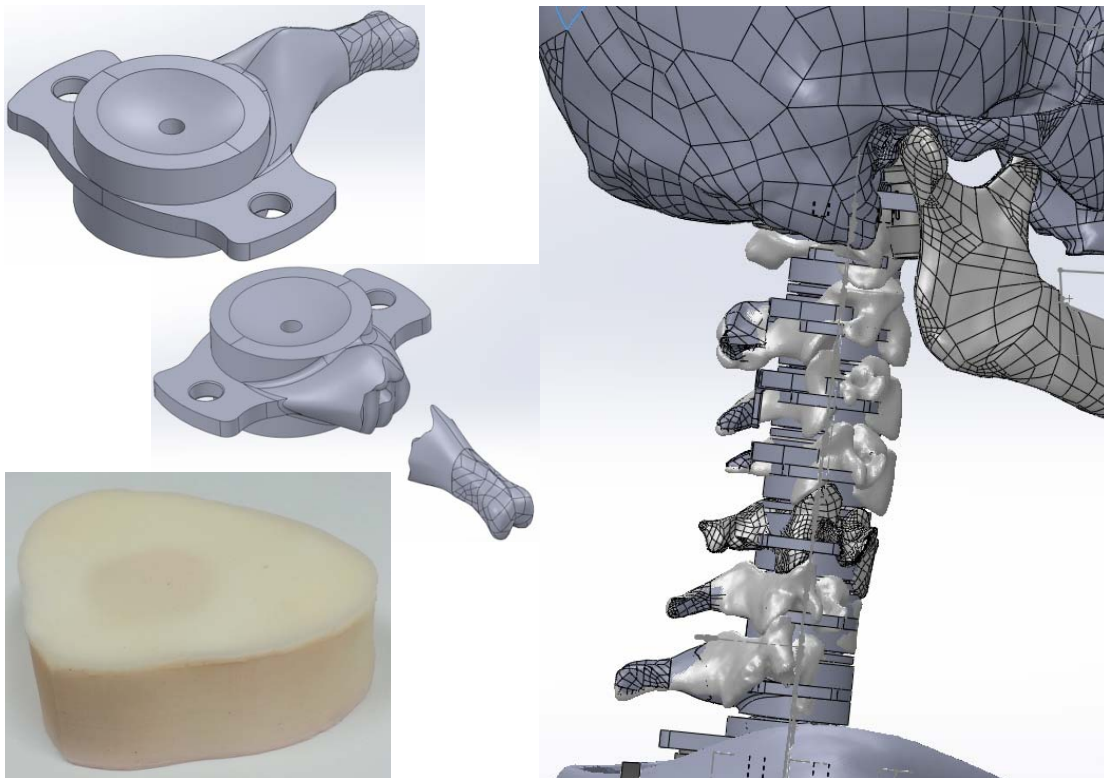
Neck element design with addition of anatomical features to the common core. Palpation test module, including neck surface contour based on CT anatomy with embedded vertebral body and fractured spinous process.
